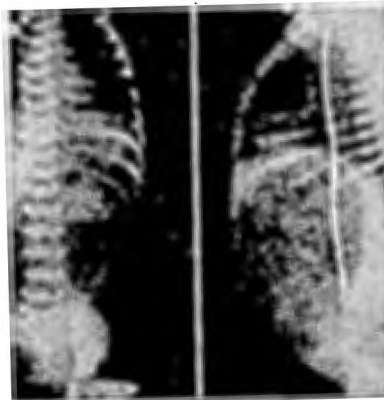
Duodenal atresia demonstrated by antero-posterior and lateral radiographic views of the infant's abdomen.
